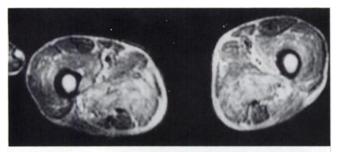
T2-weighted MRI demonstrating abnormally increased signal intensity within the proximal thigh musculature.
